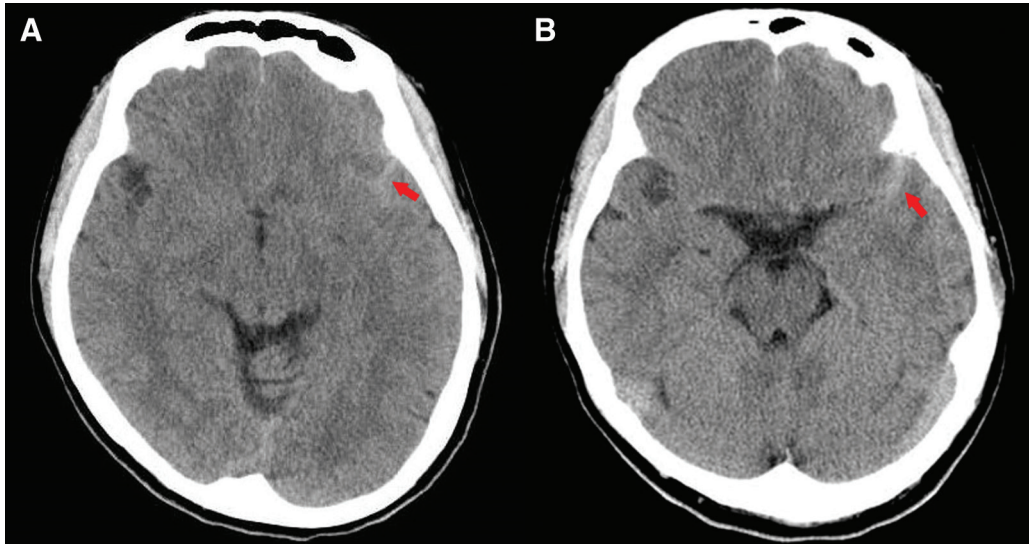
CT at the referring hospital showing SAH (arrow) in the left Sylvian fissure. SAH: subarachnoid hemorrhage
